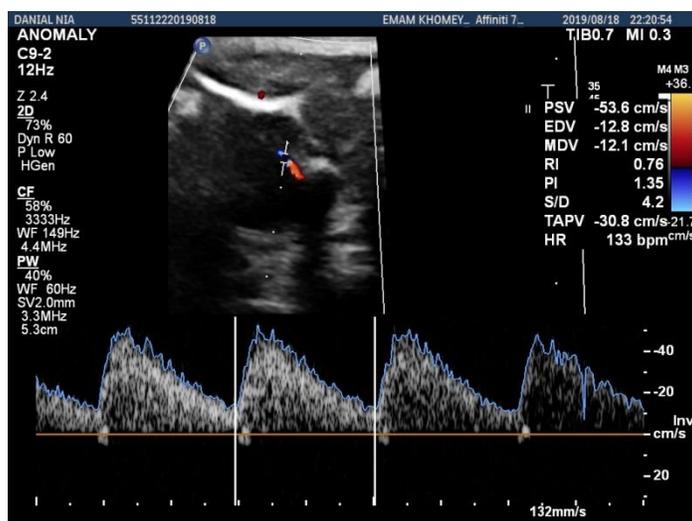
Perivesical umbilical artery Doppler
